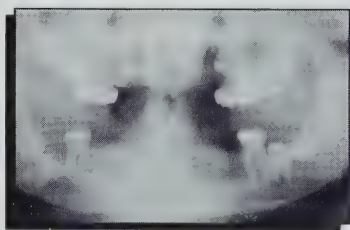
Panoramme illustrant l'état dentaire radiographique actuel.
